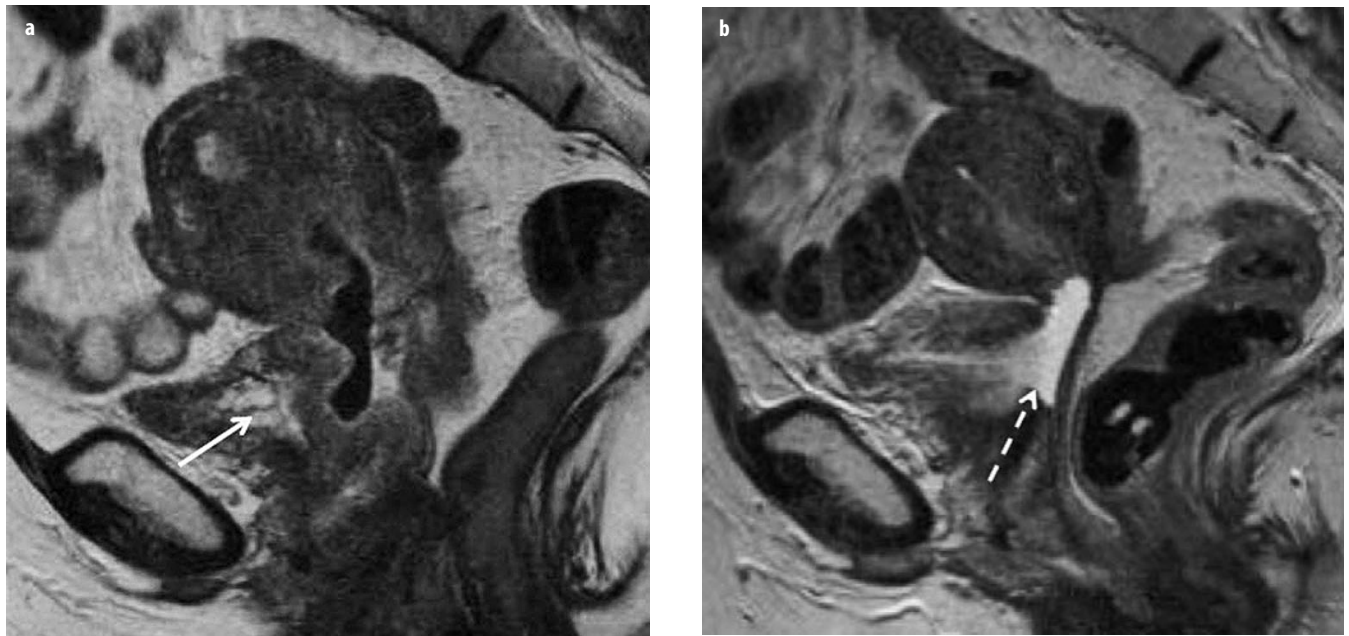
a, b. a Sagittal T2-weighted image of a large stage II cervical cancer invading the upper vagina and outer wall of the bladder. Note the presence of bullous edema of the bladder (*solid arrow*) but no frank invasion of the lumen; b development of a vesicovaginal fistula postchemoradiation therapy (*dashed arrow*)
